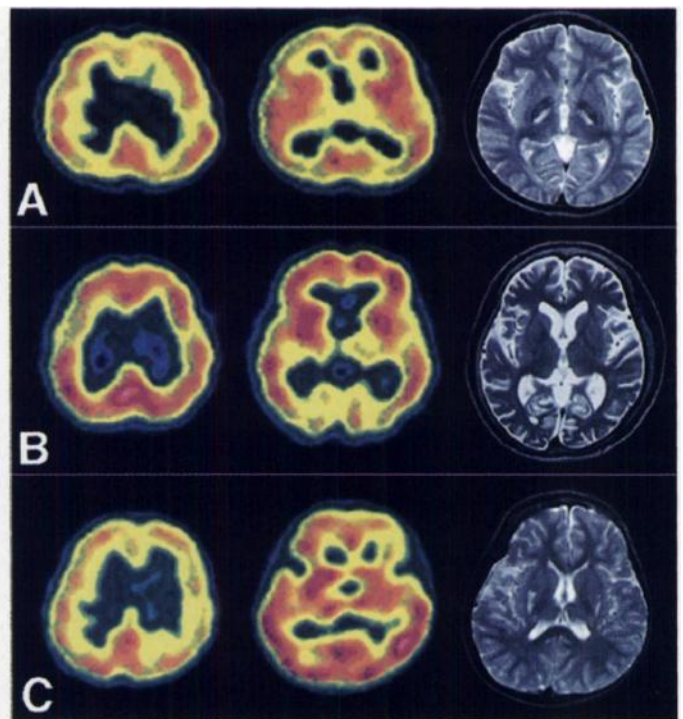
(A) SPECT and T2-weighted MRI in KSS (Patient 7), (B) MERRF (Patient 5) and (C) CCOOD (Patient 8). (A) SPECT shows normal perfusion. MRI shows a T2 prolonged area at bilateral internal capsule. (B) SPECT and MRI findings reveal no abnormalities. (C) SPECT shows normal perfusion. MRI shows a T2 prolonged area at bilateral putamen.
